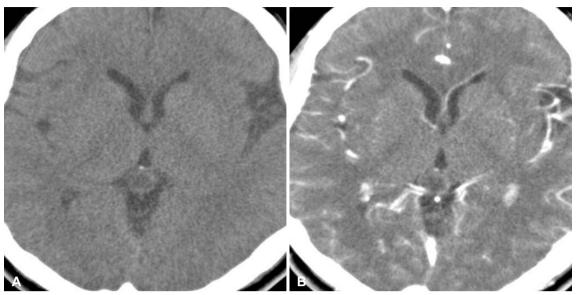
CT scans of pineal cyst apoplexy. The ventricle width is normal (A) and the cyst is mildly enhanced at the periphery (B).
